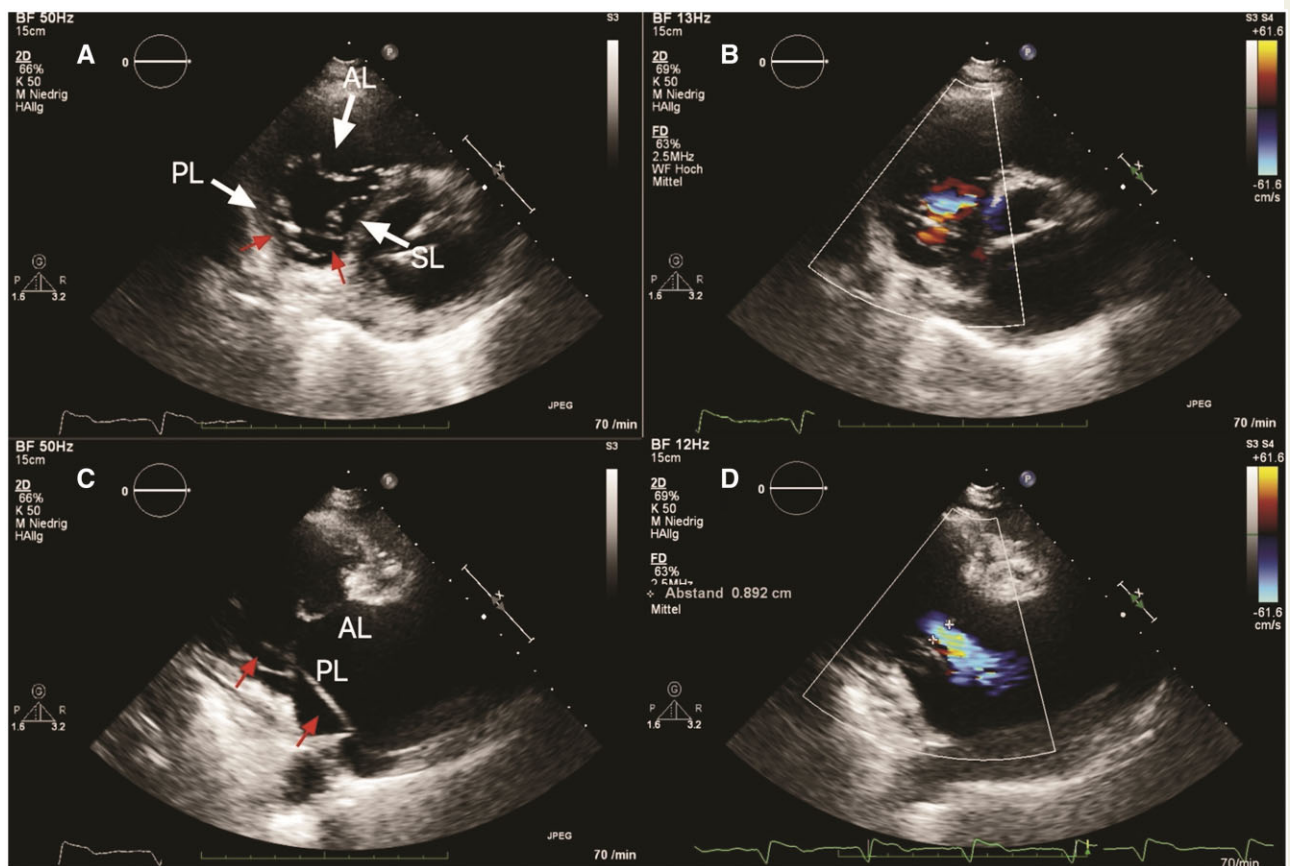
Transthoracic assessment of tricuspid valve anatomy depicting all leaflets and pacemaker lead position. (A) Transthoracic echocardiography parasternal short-axis view; red arrows → pacemaker lead; white arrows → tricuspid valve leaflets. AL, anterior leaflet; PL, posterior leaflet; SL, septal leaflet. (B) Colour flow Doppler of the same view. (C) Transthoracic echocardiography parasternal long-axis (right ventricular inflow) view; red arrows → pacemaker lead. (D) Colour flow Doppler of the same view.
